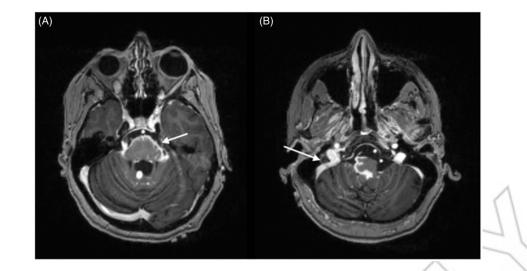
MRI brain, axial T1 post-contrast images: marked leptomeningeal enhancement at the base of the skull including along the midbrain (A) (arrow), surrounding the pons/medulla and along cranial nerves VII (B) (arrow). Brainstem enhancement in panel A represents involvement of pia-arachnoid with extension into Virchow–Robin spaces. Courtesy of Dr Fang Zhu, Chicago.
